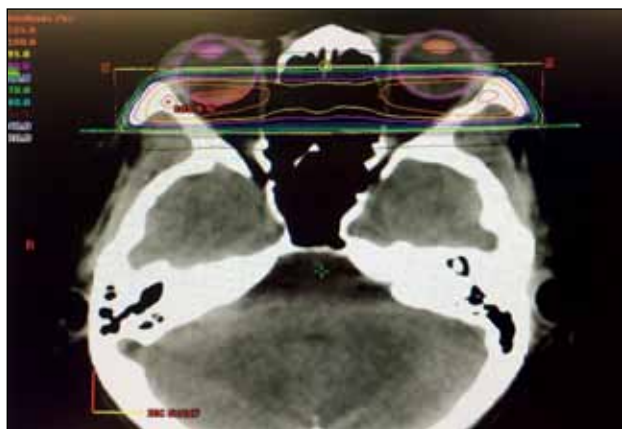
Radiotherapy dose distribution, target volume, and organ at risk delineation on axial computed tomography.
